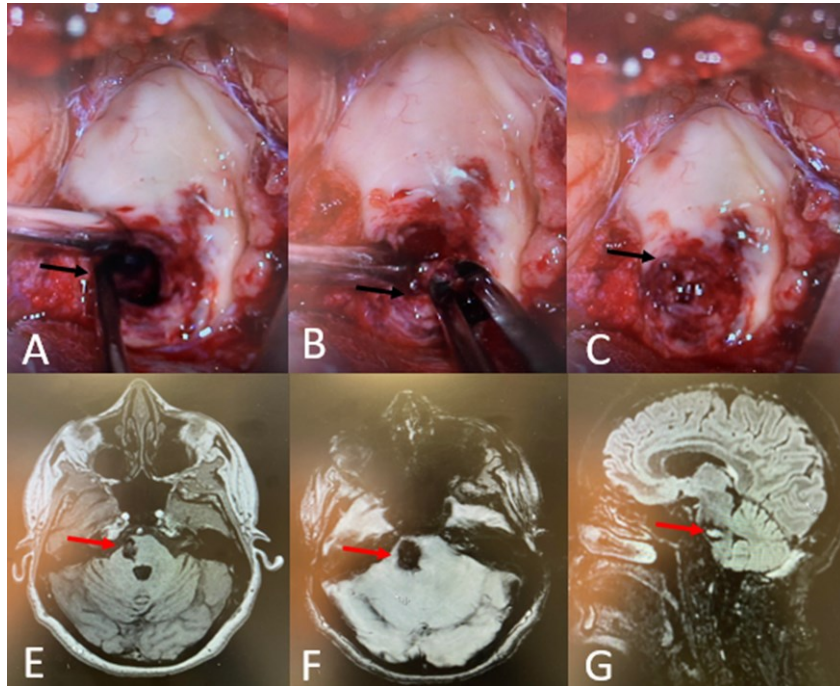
Intraoperative images and postoperatively MRI findings; (A) Intraoperative view of the right lateropontine cavernoma; (B) Intraoperative image showing excision of the cavernoma; (C) Intraoperative image after resection showing the cavity of the cavernoma; (E) Follow-up MRI at 1 month, T1-weighted showing a hyposignal reflecting the resection cavity of the lateropontine cavernoma; (F) Hyposignal SWAN sequence from the resection pocket; (G) Hypersignal Fluid-attenuated inversion recovery (FLAIR) sequence of the resection pocket.
